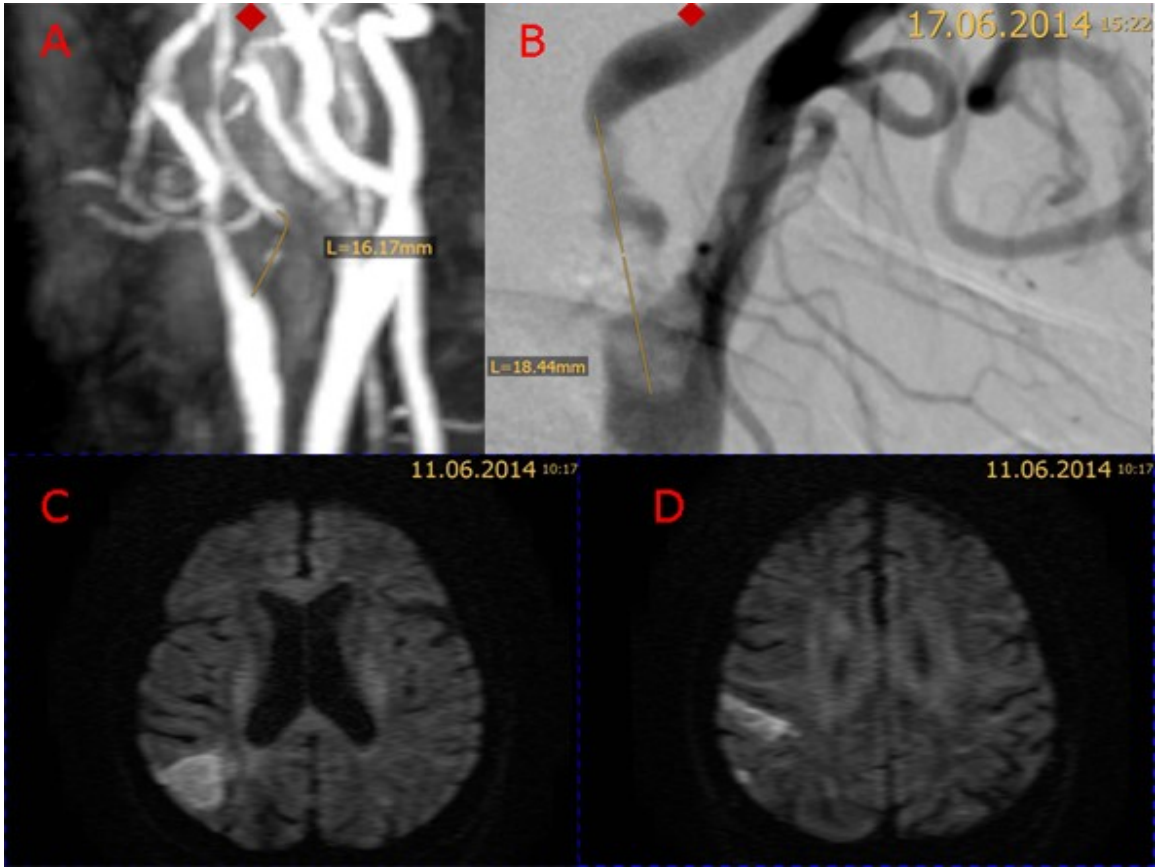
A. MRA (patient 79) showing an ICAD with a length of 16 mm on the right side, B. DSA showing an ICAD with a length of 18 mm, C and D. DWI-MRI showing infarctions within the territory of the MCA
